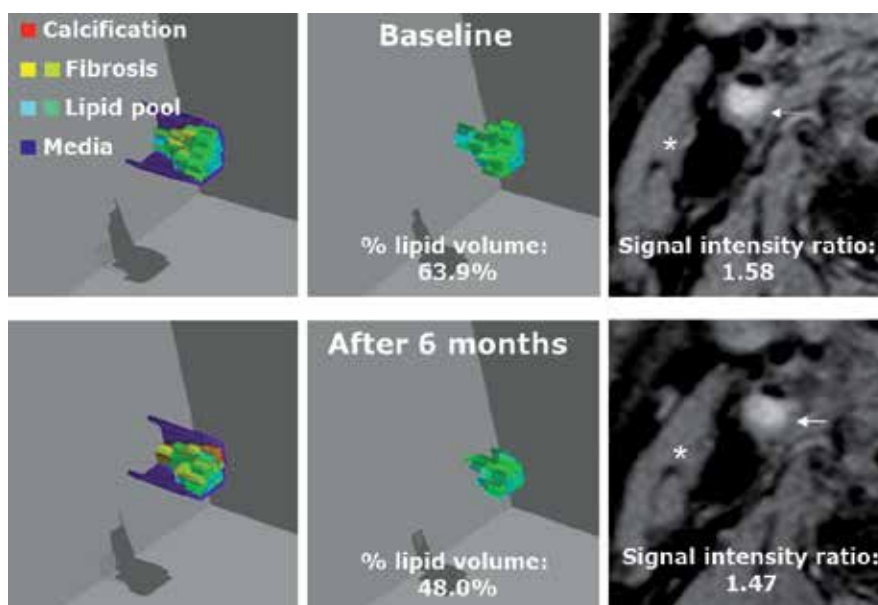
Representative images of three dimensional IBS color-coded maps. Left: Three-dimensional cut out images of color-coded maps of carotid arteries. Middle: Three-dimensional images of lipid pool. Right: High resolutional magnetic resonance images of carotid plaques.
